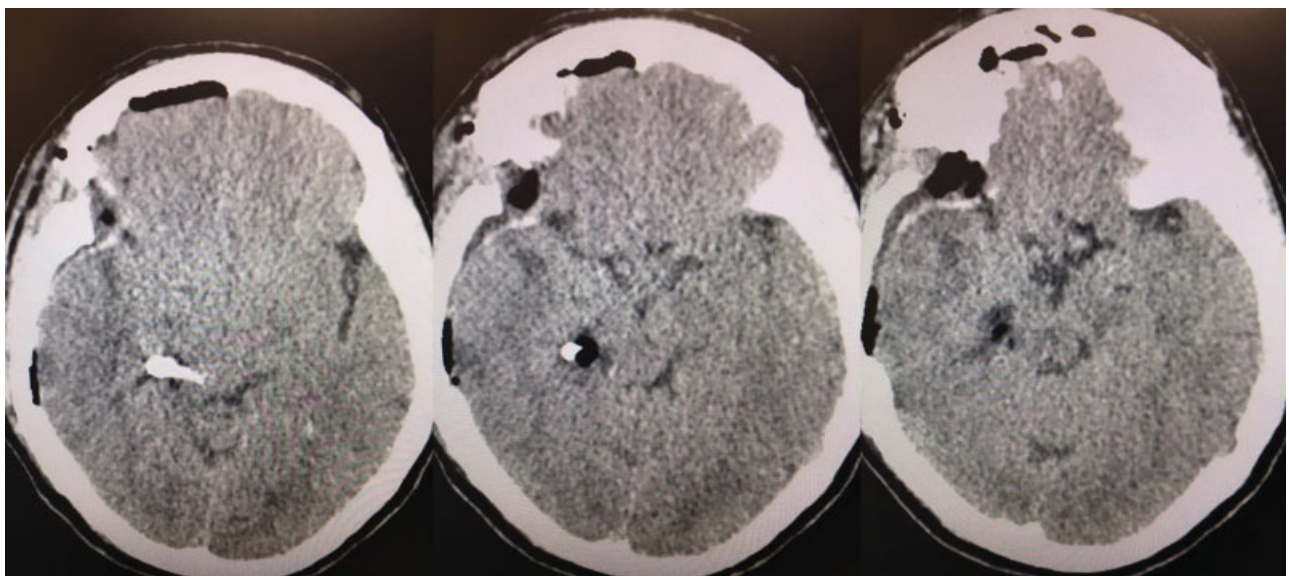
Postoperative computed tomography showing the surgical site.
